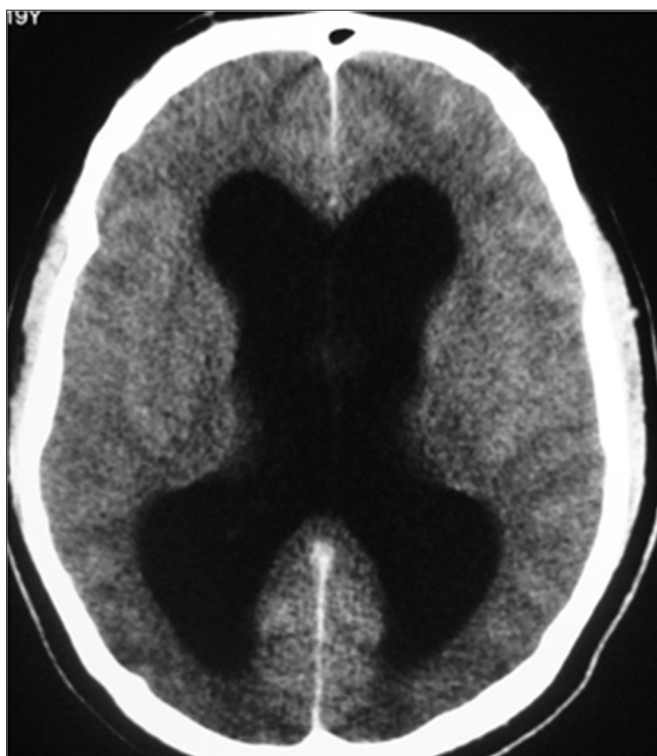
Computed Tomography Imaging without contrast. 19-year-old male with important dilatation of lateral ventricles.
